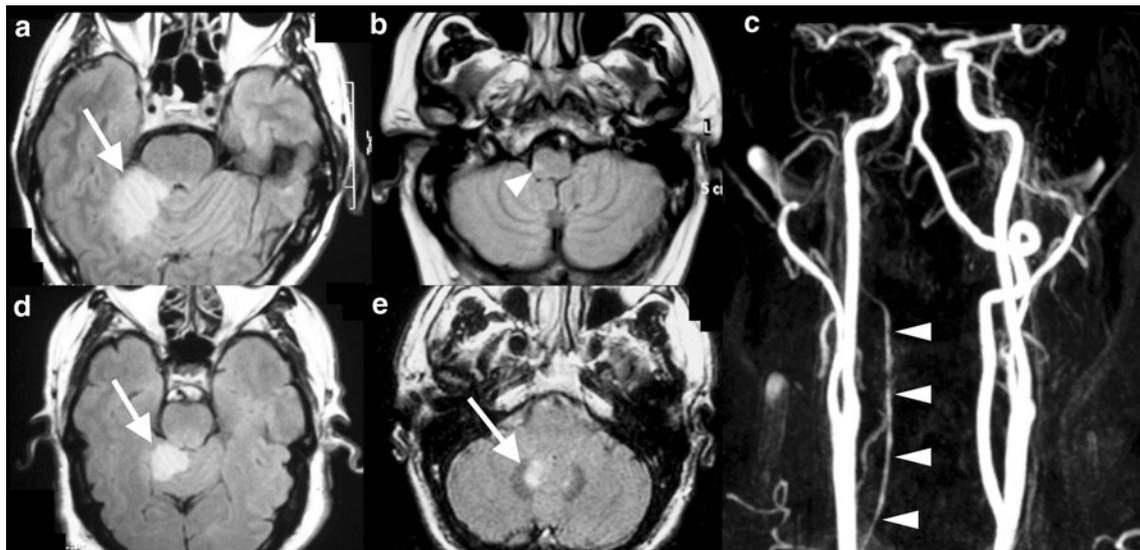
Brain MRI of patients with neurovascular disorders causing RTI: a case 1, axial FLAIR, right SCA infarction (*arrow*); b case 2, axial FLAIR, right lateral medullary infarction (*arrowhead*); c case 2, anterior-posterior view of MRA, irregular narrowing of the whole course of the right vertebral artery (*arrowheads*); d case 3, axial
